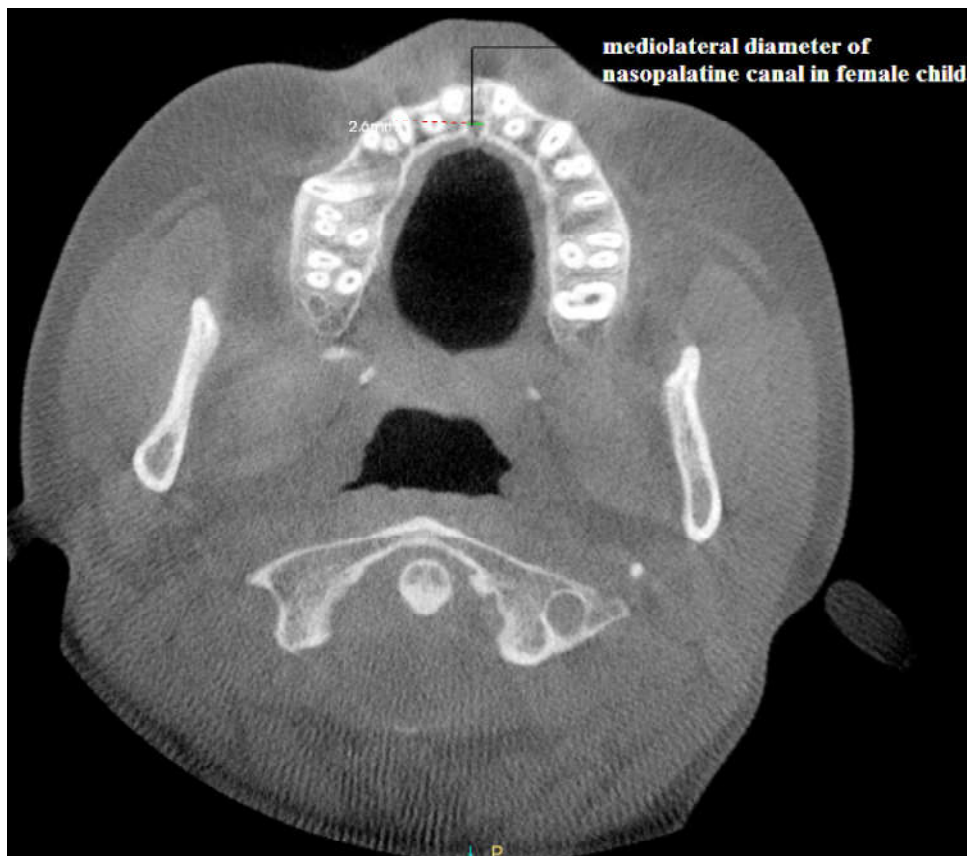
Axial section (CBCT) showing mediolateral diameter of nasopalatine fossa in female subject
